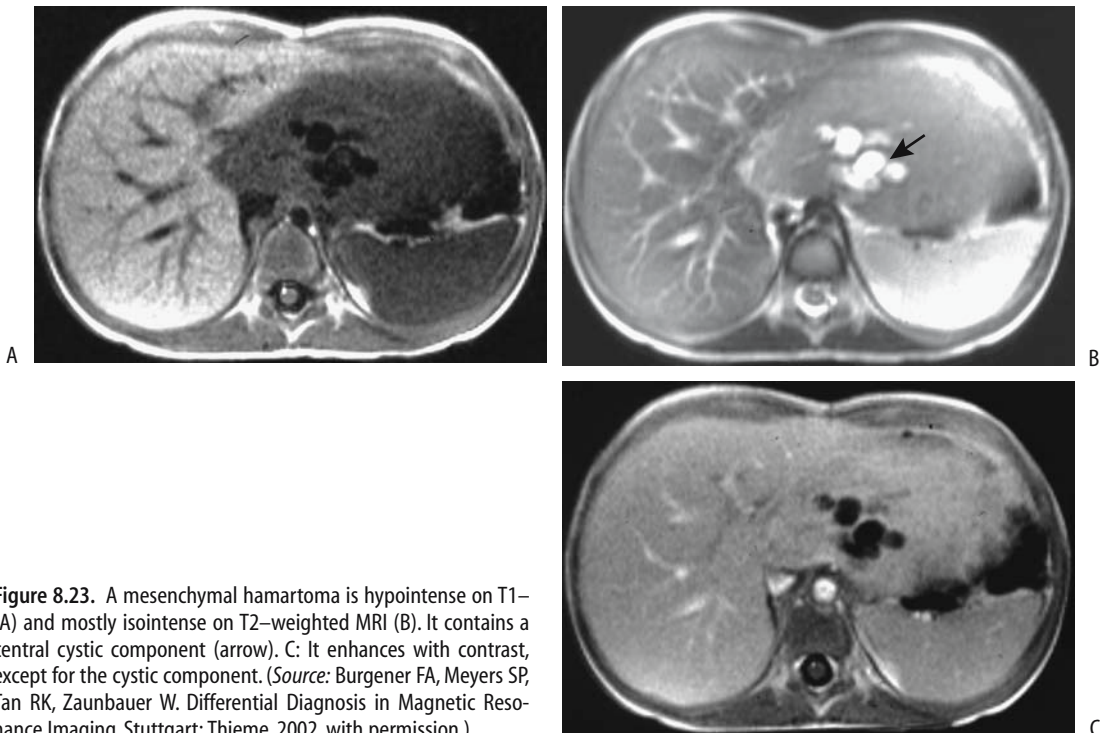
A mesenchymal hamartoma is hypointense on T1- (A) and mostly isointense on T2-weighted MRI (B). It contains a central cystic component (arrow). C: It enhances with contrast, except for the cystic component. (Source: Burgener FA, Meyers SP, Tan RK, Zaunbauer W. *Differential Diagnosis in Magnetic Resonance Imaging*. Stuttgart: Thieme, 2002, with permission.)
